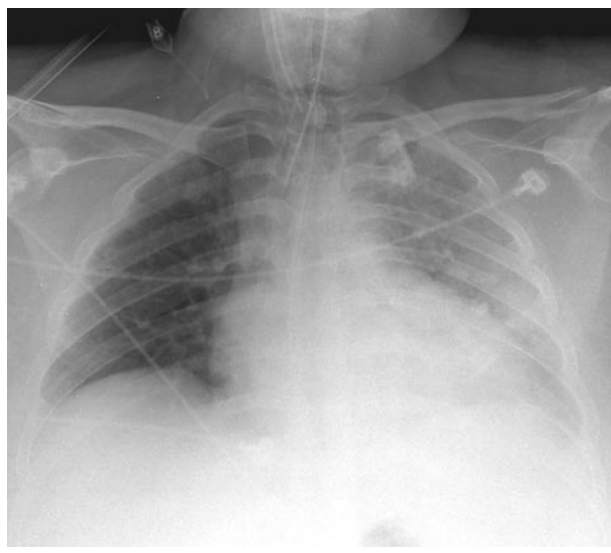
Repeat chest radiograph, four hours after the event, showing mild improvement in left lung edema.
